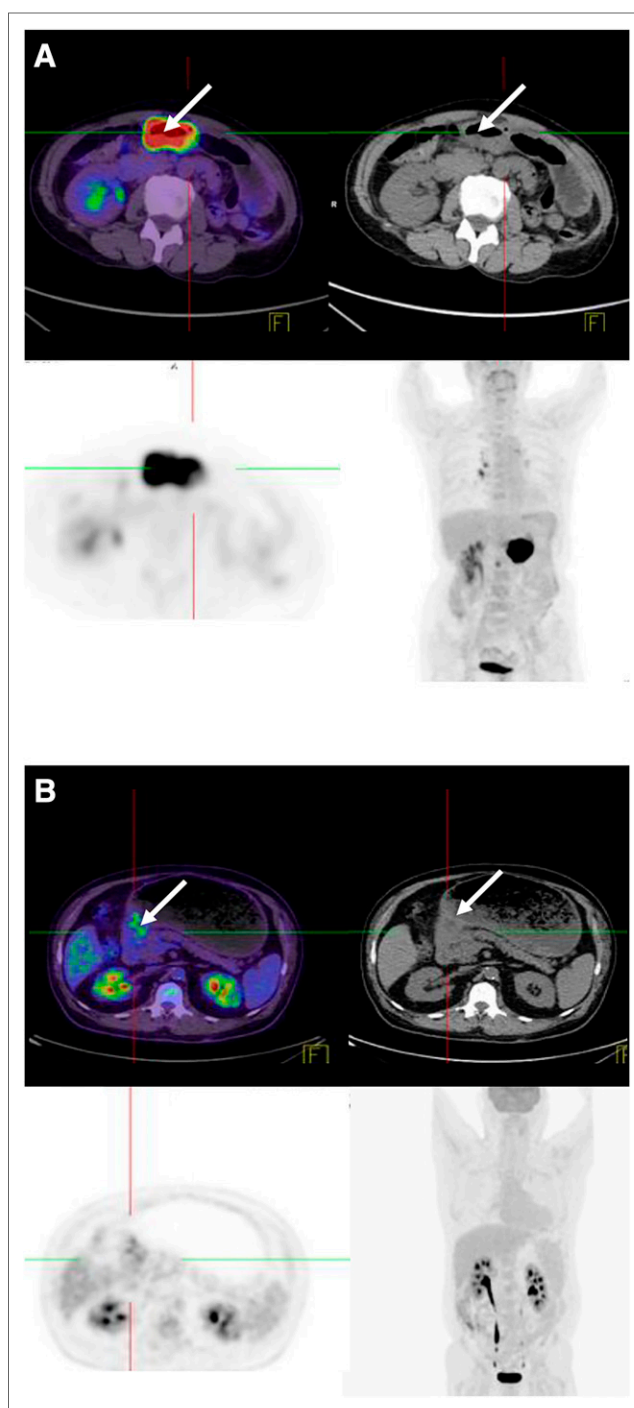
^{18}F -FDG PET/CT image of avid and nonavid gastric adenocarcinoma. (A) Avid gastric adenocarcinoma shows intense uptake in gastric antrum, and corresponding CT image demonstrates thickening of gastric antrum wall (arrow). Nonavid gastric adenocarcinoma (B) shows minimal uptake in pylorus (considered to be physiologic), with marked focal thickening on corresponding CT image consistent with site of known primary tumor (arrow).
